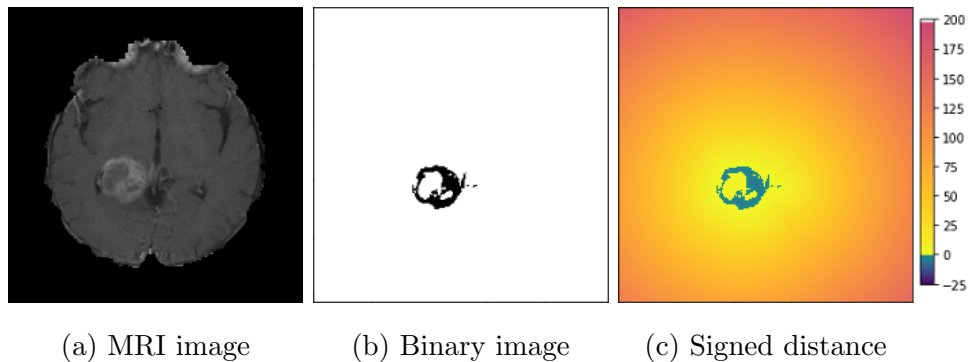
The T1-weighted contrast-enhanced MRI image of GBM patient (left), segmented binary image (middle), and signed distance transformed image (right). In the signed distance transformed image, the tumor regions are colored from blue to green and the normal regions are colored yellow to red.
